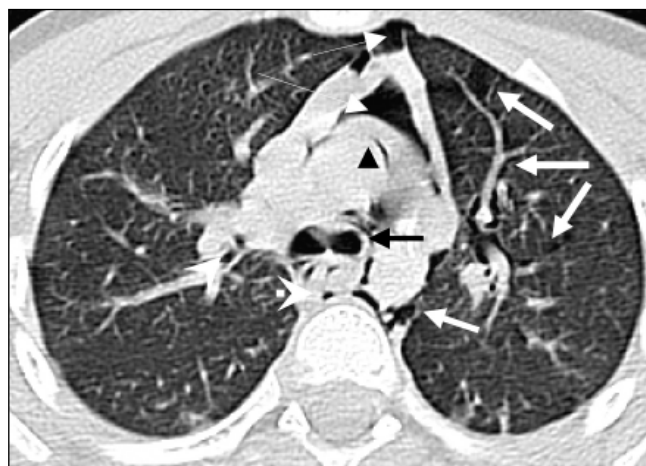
Axial CT image of the upper mediastinum demonstrating pulmonary interstitial emphysema of the left upper lobe (thick white arrows) as well as mediastinal air surrounding the thymus (thin white arrows), ascending aorta (black arrowhead), descending aorta (hollow white arrow), azygous (white arrowheads), and main stem bronchi (black arrow).
